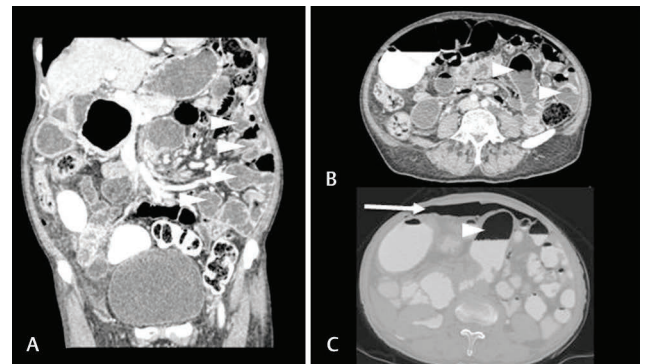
Coronal reformatted CT image (A) and axial image (B) in venous phase, show multiple jejunal diverticula (white arrowheads). (C) Axial CT image in delayed phase with positive oral contrast, in bone window, shows pneumoperitoneum (white arrow). Large duodenal diverticulum with air contrast level can be seen in left paramedian location (arrowhead). CT, computed tomography;
